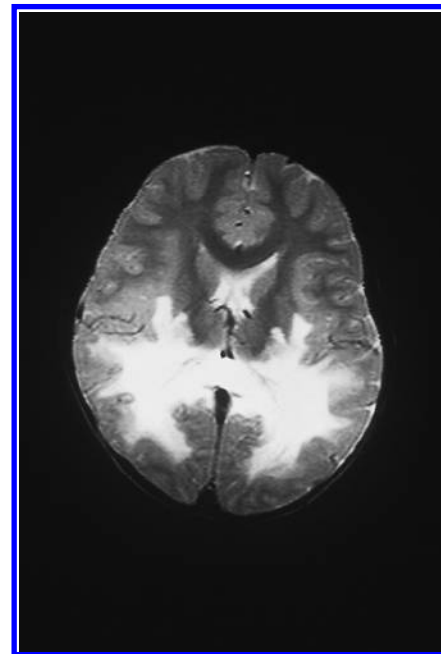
Magnetic resonance image of the brain of GQ, a seven-year-old boy with adrenoleukodystrophy. He had experienced the sudden onset of seizures after a period of disturbed behavior. He had pyramidal tract signs and spatial agnosia. Imaging revealed the typical white matter disease.
